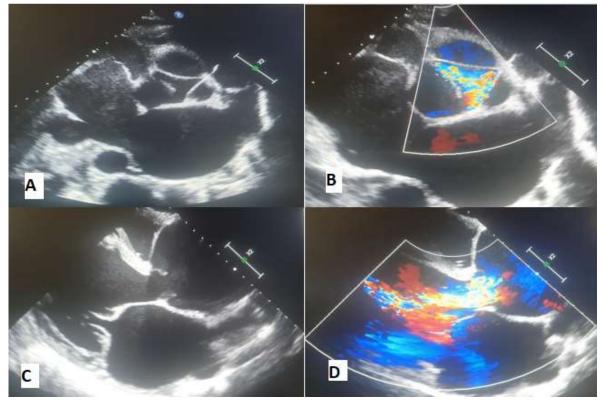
Transthoracic echocardiogram showing 89 cm ascending aortic aneurysm without dissection at the level of sinus of valsalva (C) and severe aortic regurgitation (A,B,D)
